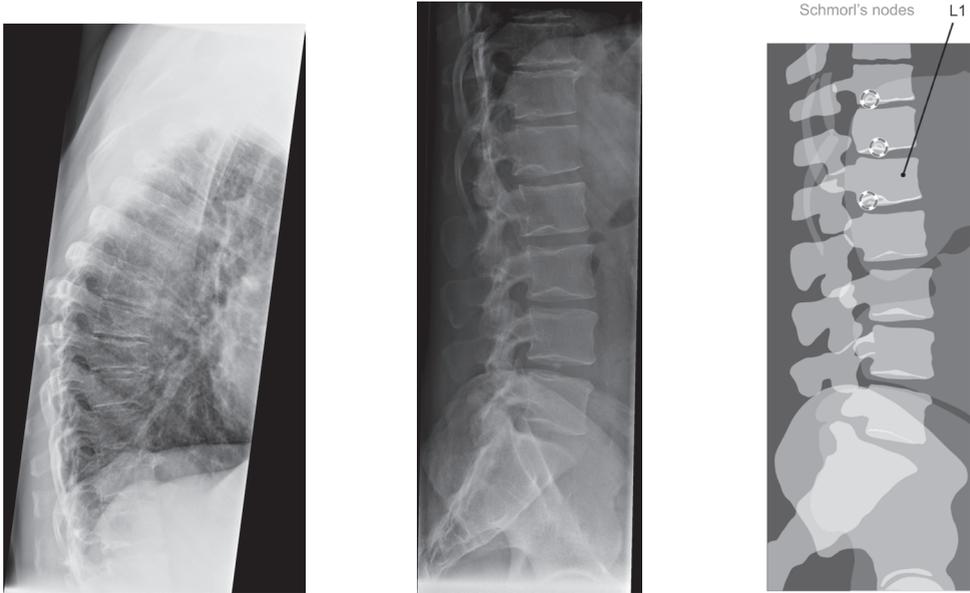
Lateral radiographs of the thoracic and lumbar spine in patient A, a 56-year old man. There is enhanced kyphosis with anterior height loss of mid-thoracic vertebrae T6-9 and Schmorl's nodes on vertebral levels T11 to L1 (arrows). The thoracic vertebral endplates display irregularities and degenerative osteophyte formation.
